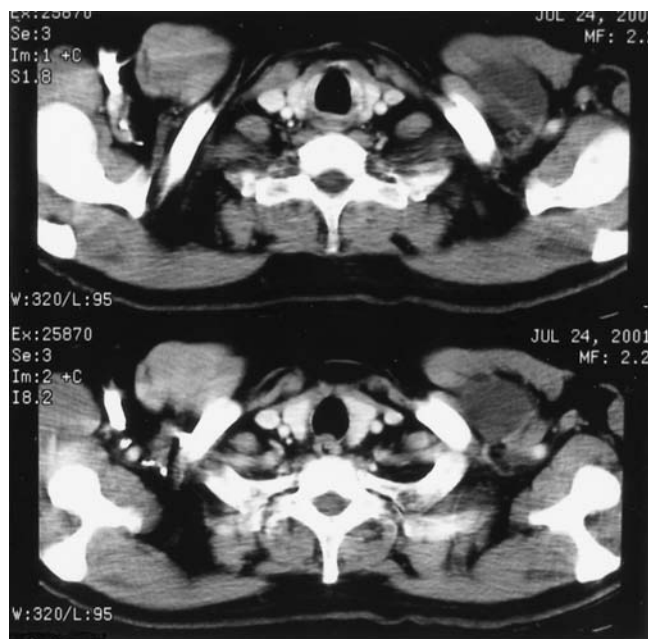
Computed tomographic scanning showed a 2 × 4-cm cystic mass with a smooth outline, over the left infraclavicular region adjacent to the left chest wall
